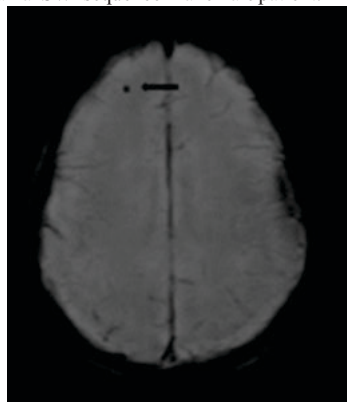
Tiny hemosiderin deposit on follow-up MRI on axial SWI image – a sequelae of right frontal venous infarct in a young female patient presenting with seizures and headache (diagnosed eight months back in outside hospital)
